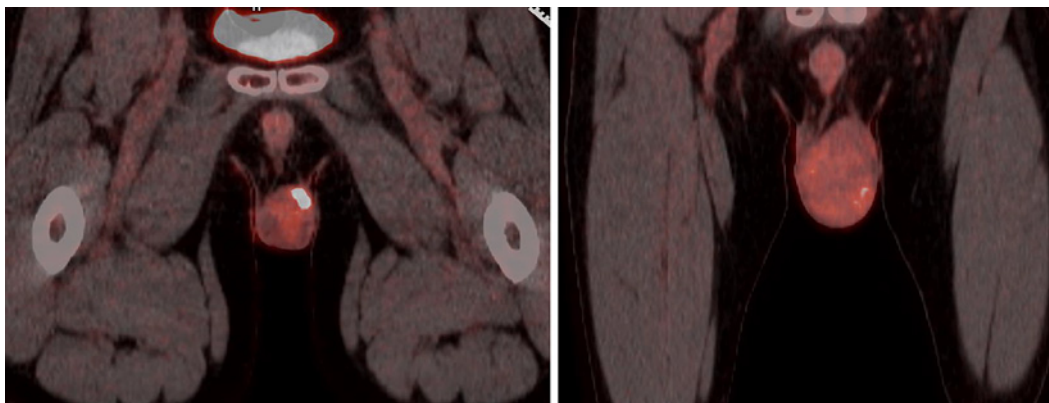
^{18}F FDG fused coronal FDG PET/CT images, which revealed heterogenous increased metabolic activity in enlarged left testis. PET, positron emission tomography; CT, computed tomography.
